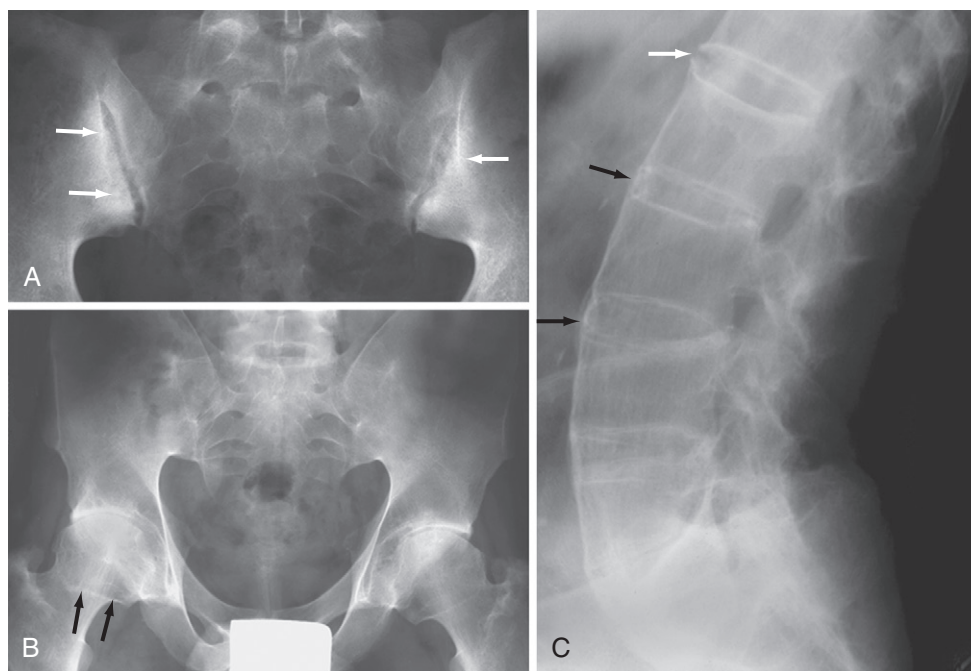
Ankylosing spondylitis (x-ray). A, Sclerosis (arrows) is seen along the iliac sides of the sacroiliac joints, along with loss of portions of the iliac subchondral bone indicating erosion. B, Bilateral hip joint space narrowing is present. A ring of osteophytes is noted at the synovial insertion (arrows) on each femoral head. The sacroiliac joints are fused (ankylosis). C, Syndesmophytes (black and white arrows), some of which extend from the edge of one vertebral body to the next (bridging syndesmophytes, ankylosis; black arrows), are seen in this lateral view of the spine.
